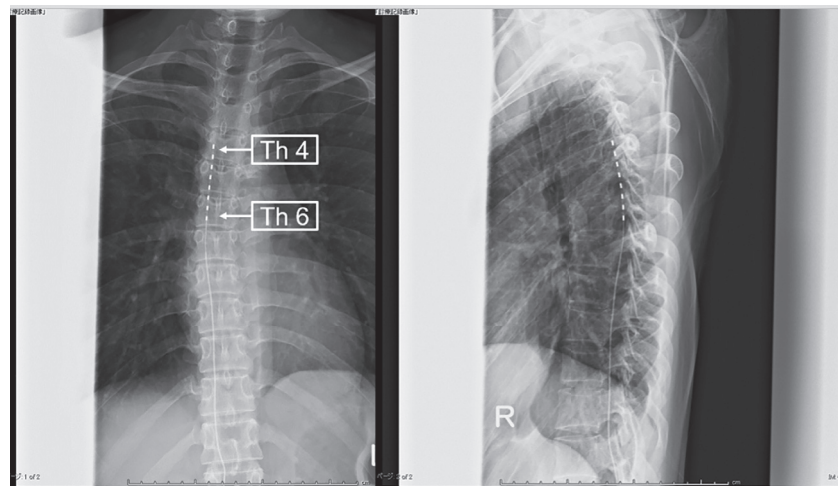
Chest X-ray after placement of an 8-pole electrode
